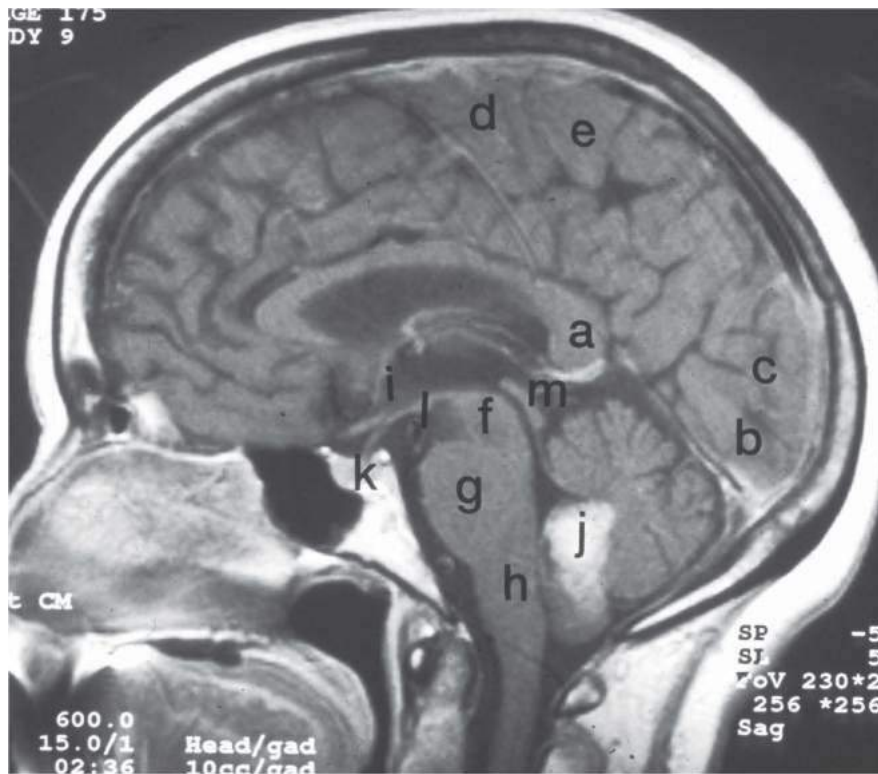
MRI of Medial View of the Central Nervous System
